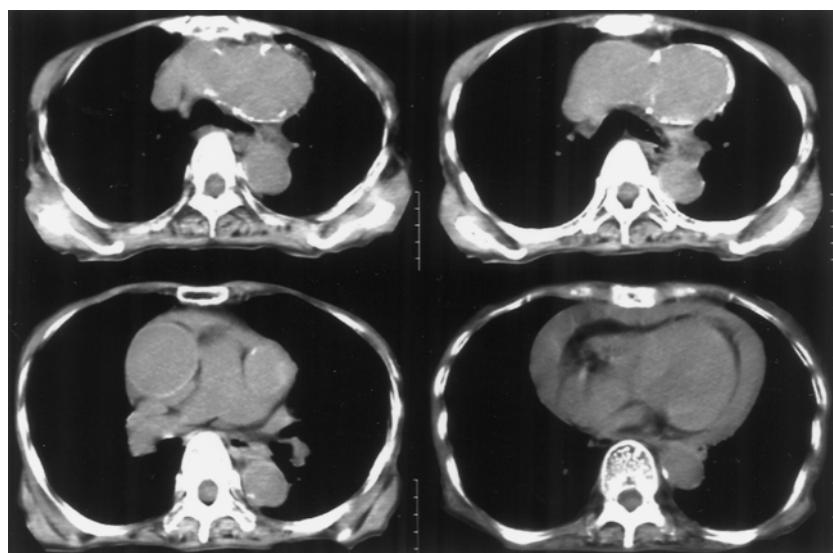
CT showing a distal aortic arch aneurysm and massive pericardial effusion.
